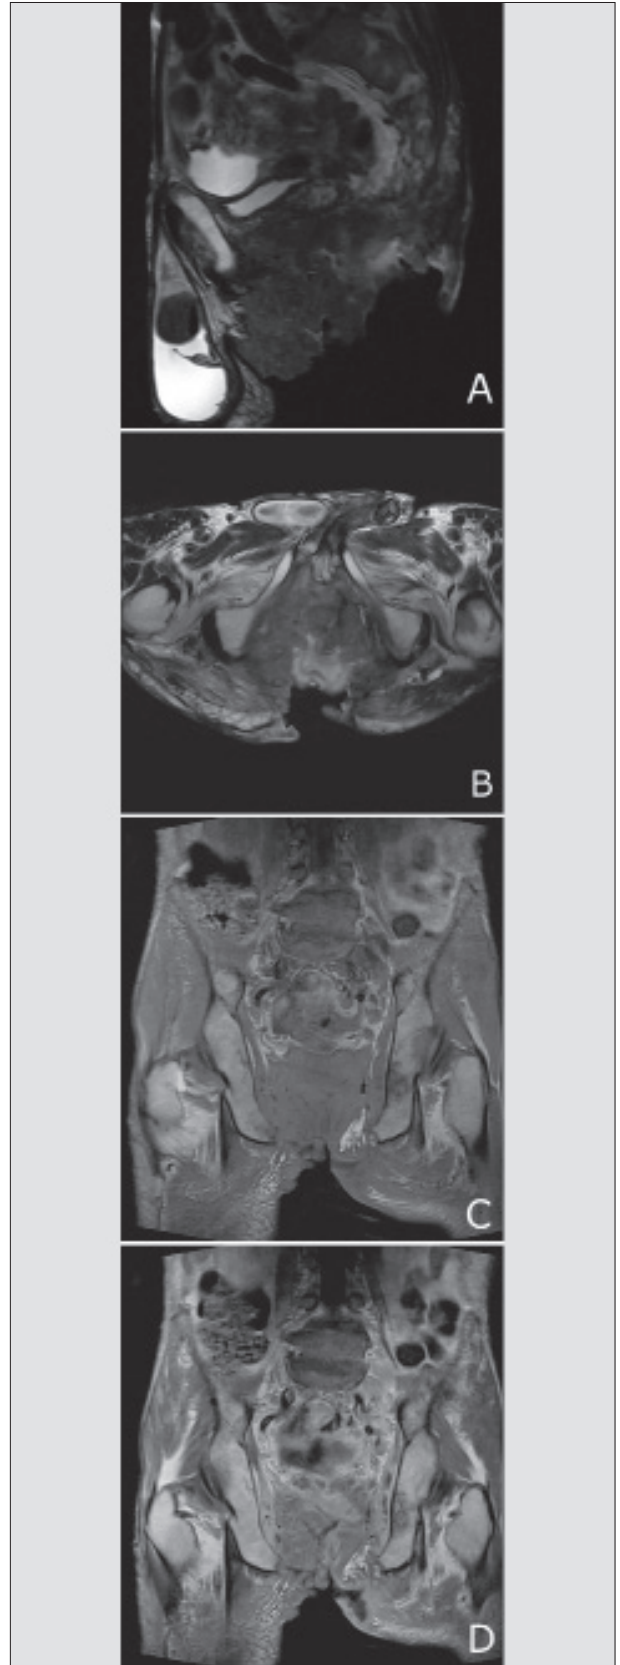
Magnetic resonance imaging of the pelvis, performed with a patient in prone position, shows the extensive vegetant lesion infiltrating the pelvic floor (A – T2W sagittal image), inner gluteal region bilaterally (B – T2W axial image) with invasion of the anus, urinary bladder, scrotum, penis, sacrococcygeal and pubic bone (C – T1W coronal image). Intensive postcontrast enhancement of infiltrating tissue is present (D – contrast enhanced T1W coronal image). Enlarged parailiac lymph nodes are evident (C, D).
